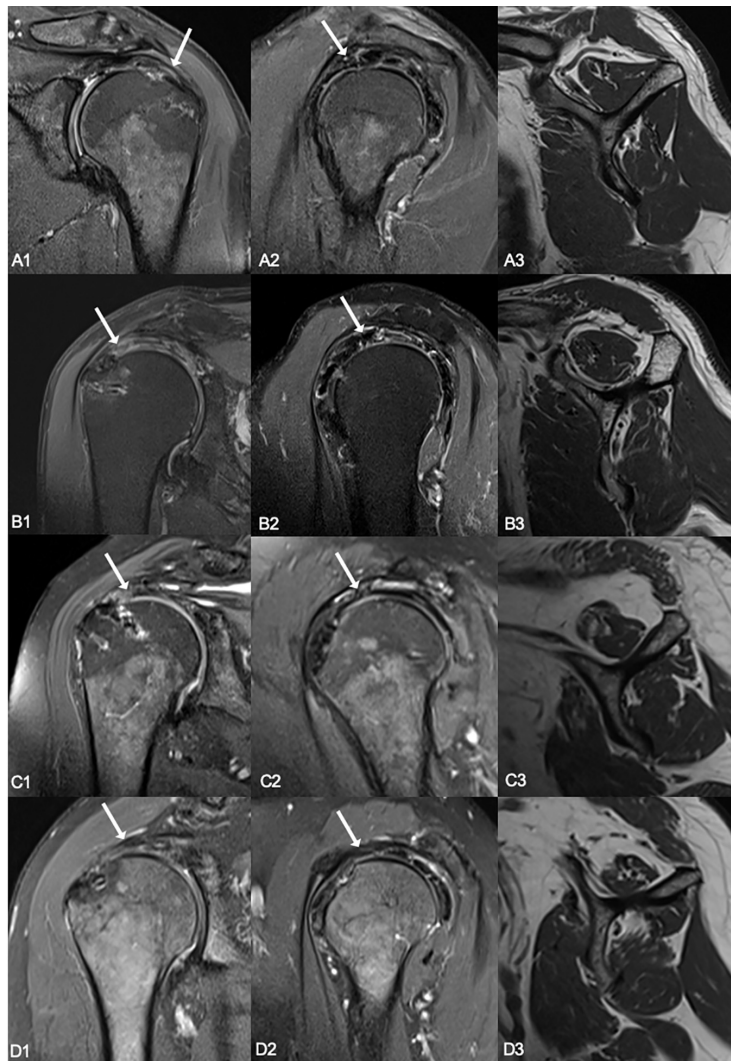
Imaging of patients who had an intact superior capsular graft at 3 years. Intact graft (straight white arrow) on proton density fat-saturated (A1) coronal and (A2) sagittal magnetic resonance imaging (MRI) scans and (A3) fatty degeneration of the rotator cuff muscles on T1-weighted sagittal MRI scan of the left shoulder of patient 2. Intact graft (straight white arrow) on proton density fat-saturated (B1) coronal and (B2) sagittal MRI scans and (B3) fatty degeneration of the rotator cuff muscles on T1-weighted sagittal MRI scan of the right shoulder of patient 8. Intact graft (straight white arrow) on proton density fat-saturated (C1) coronal and (C2) sagittal MRI scans and (C3) fatty degeneration of the rotator cuff muscles on T1-weighted sagittal MRI scan of the right shoulder of patient 16. Intact graft (straight white arrow) on proton density fat-saturated (D1) coronal and (D2) sagittal MRI scans and (D3) fatty degeneration of the rotator cuff muscles on T1-weighted sagittal MRI scan of the right shoulder of patient 22.
